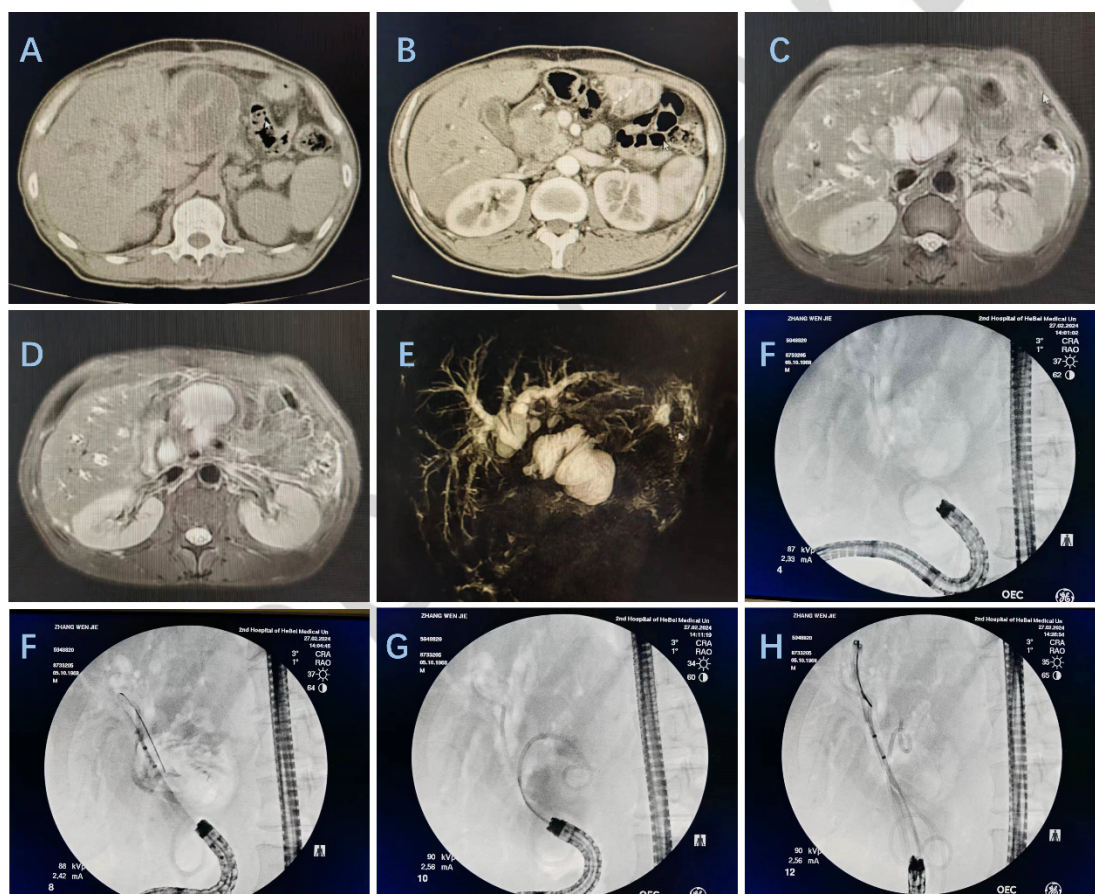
A-E: Abdominal CT and MRCP showed biliary duct dilation and input loop intestinal duct dilation. F-H: Stent placement of bile duct and intestine under wire superselection.
